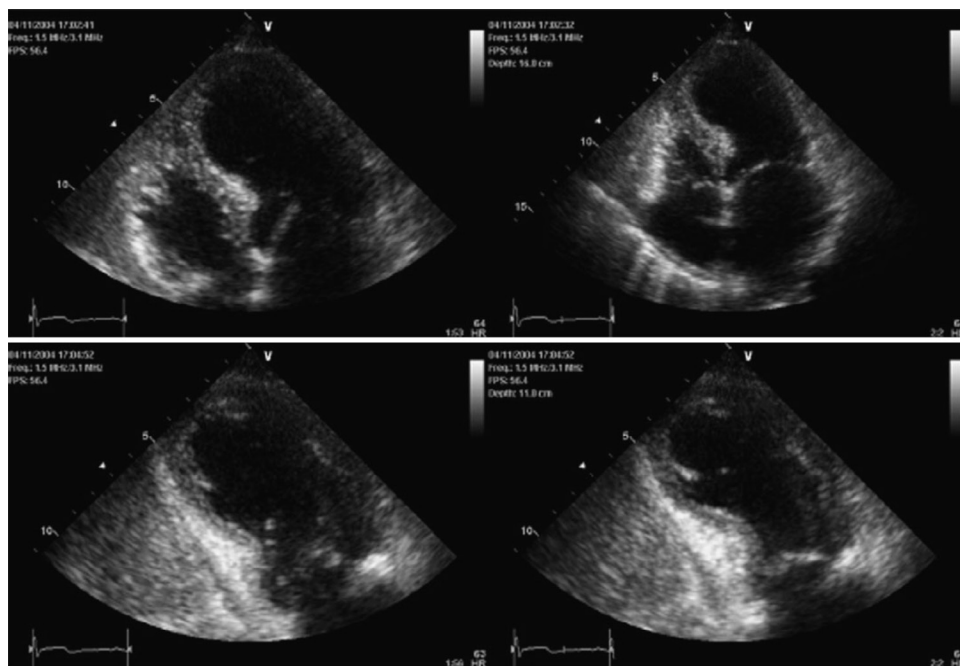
■ End-diastolic and end-systolic apical four- and two-chamber echocardiographic views demonstrating the typical apical and mid-ventricular LV wall motion abnormalities of a patient with transient apical ballooning syndrome. (From Gianni M, Dentali F, Grandi AM, Sumner G, Hiralal R, Lonn E. Apical ballooning syndrome or takotsubo cardiomyopathy: a systematic review. *Eur Heart J* 2006;27:1523–9.)
